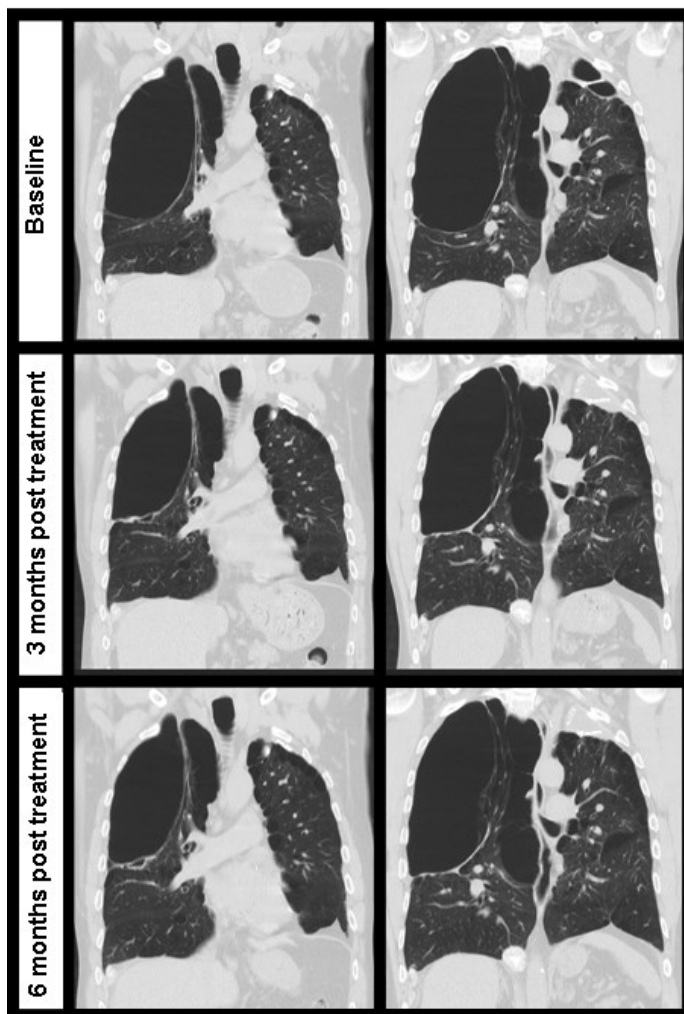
Coronal HRCT scan images from subject 2 at baseline, 3, and 6 months following BIABI treatment. There is a reduction in bulla size 3 months after treatment and new thickening and fibrosis of the inferior bulla lining can be appreciated. No subsequent change was seen between 3 and 6 months following treatment.
